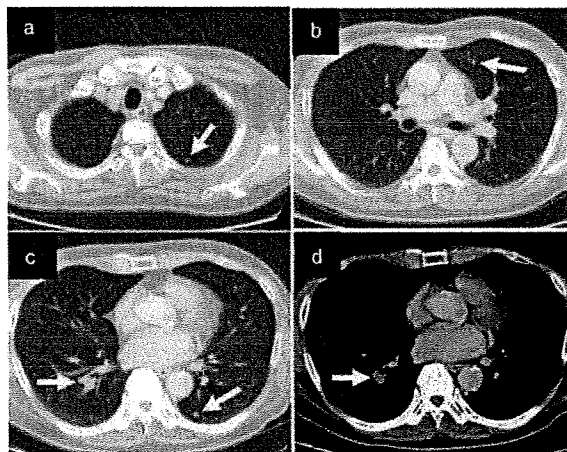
(a–d) Chest computed tomography showed multiple pulmonary metastases in both lung fields (arrows), five months after posterior segmentectomy.
